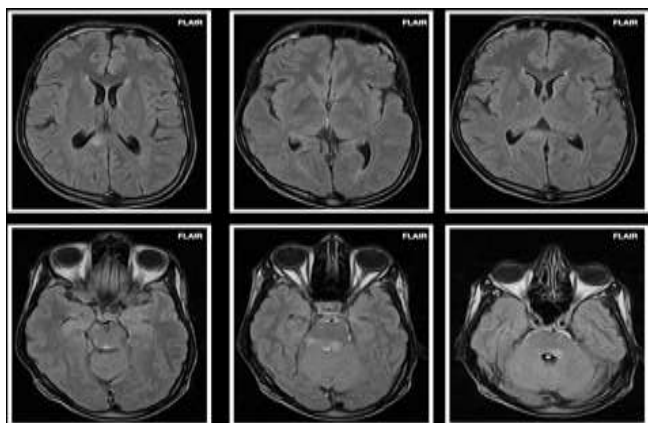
FLAIR hyperintense signal involving the splenium of corpus callosum on right side, bilateral gangliocapsular regions, midbrain and pons suggestive of Focal Altered Signal Intensities – (FASI) in a case of 22 year old male with Neurofibromatosis 1.
